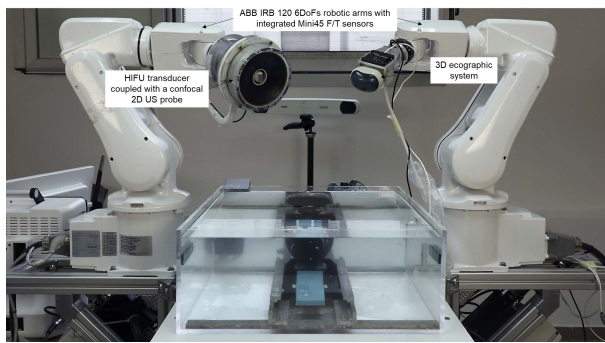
FUTURA (Focused Ultrasound Therapy Using Robotic Approaches) platform for high-intensity focused ultrasound surgery guided by ultrasound imaging [54].
